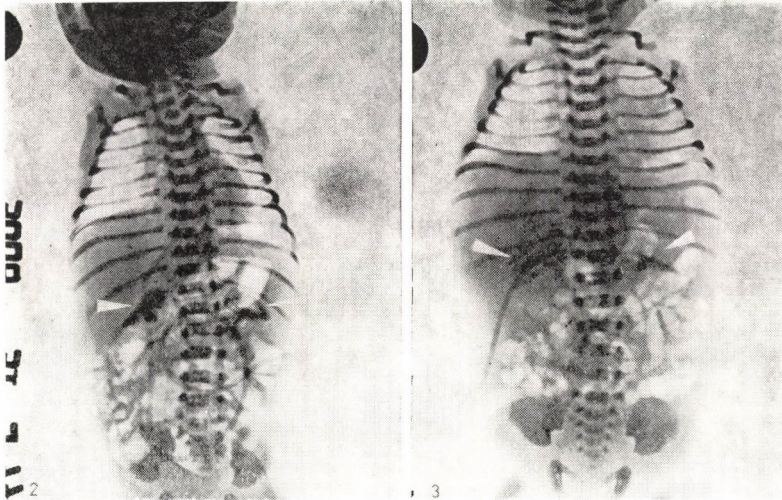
Plain abdominal X-ray of twin B at three hours of age. The cap-shaped calcifications in both adrenal regions are indicated by arrows
